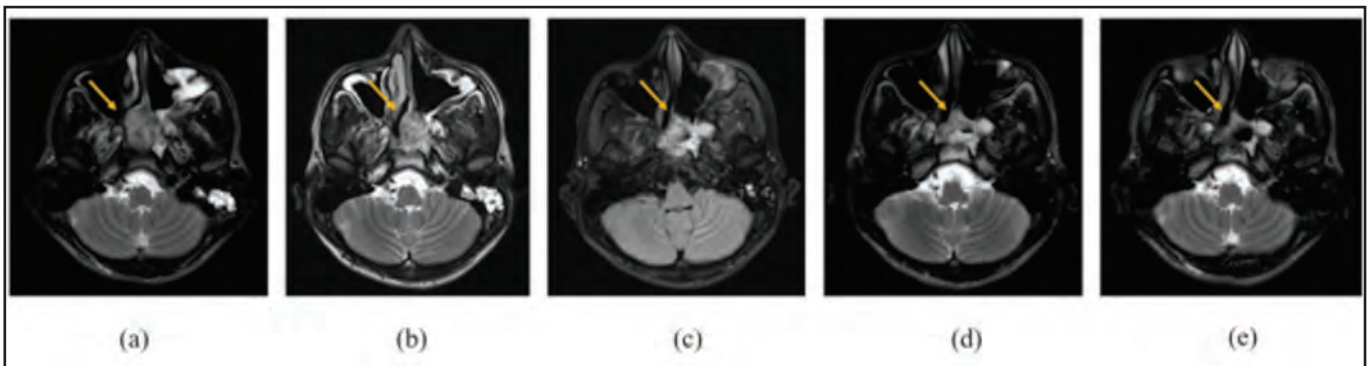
Serial magnetic resonance imaging (MRI) T2 images showing tumour size: (a) Pre-radiotherapy (RT) (AP 3.7 × LL 2.6 × CC 2.73 cm), (b) 6 weeks after RT, (c) 6 months after RT, (d) 12 months after RT, and (e) 18 months after RT (AP 2.5 × LL 2.13 × CC 1.3 cm)
